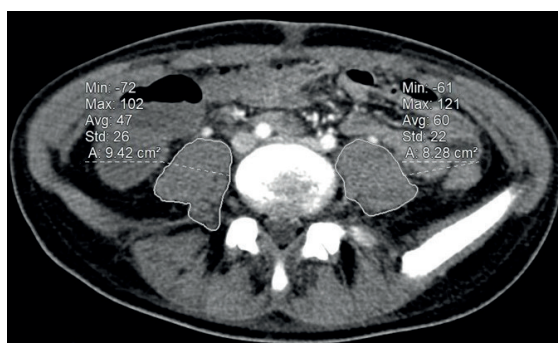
Transverse contrast enhanced abdominal CT image shows bilateral psoas muscle area measurement at L4-5 level.
